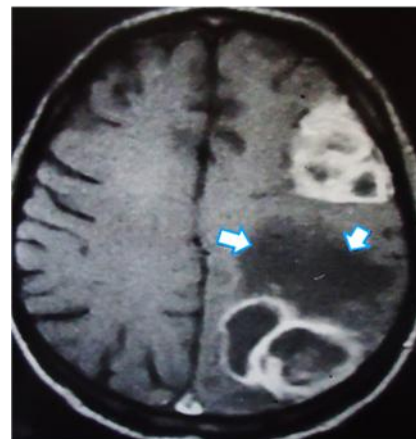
CT image of multiple brain abscesses
